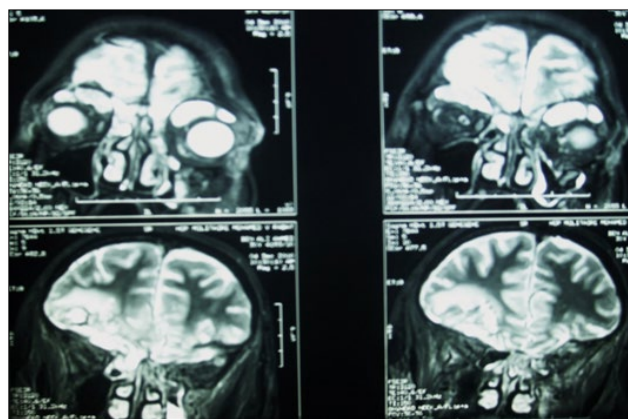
Brain MRI showed increased volume of frontal contusion and an intra-orbital encephalocele bilateral.
